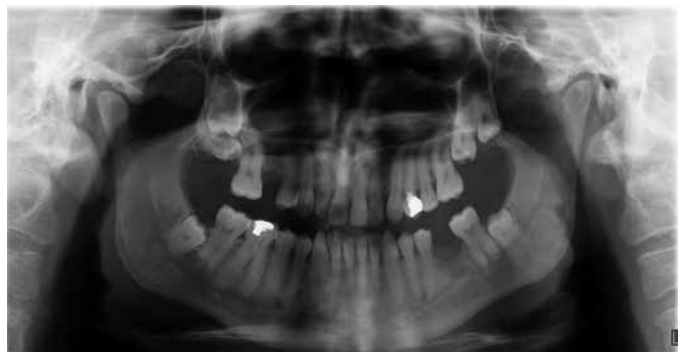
Pre-operative panoramic radiograph showing impacted third molar and supernumerary teeth.
